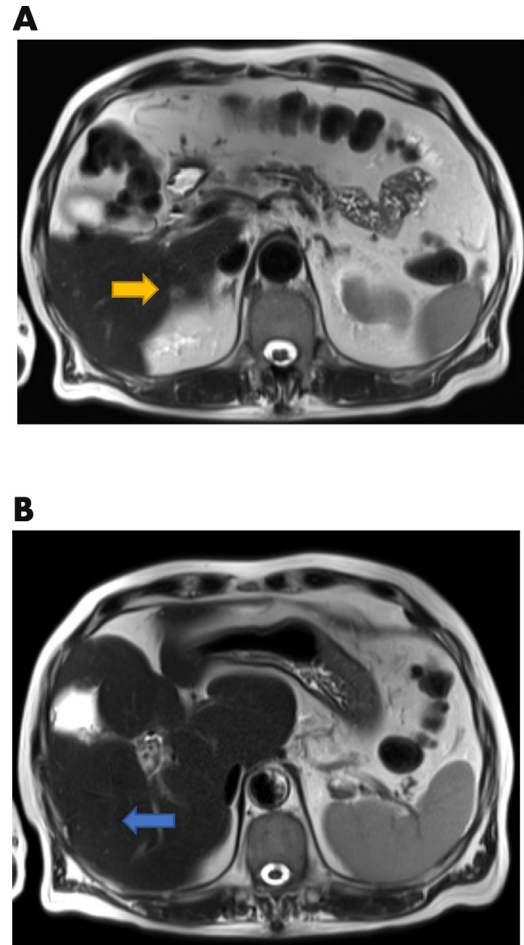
Follow-up MRI liver on axial T2 sequence showing near-resolution of segment 5 and 6 liver lesion (A) (yellow arrow) and segment 8 lesions (B) (blue arrow).
